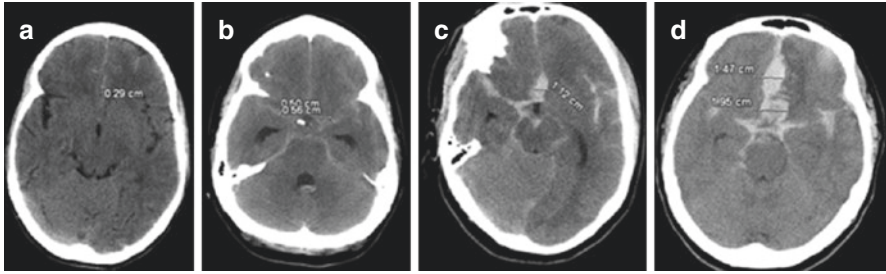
These four axial CT images of patients show different amounts of subarachnoid hemorrhage. In the Fisher scale, all four are grade 3, whereas in the Wilson scale (a) would be 2, (b) would be 3, (c) would be 4, and (d) would be 5
